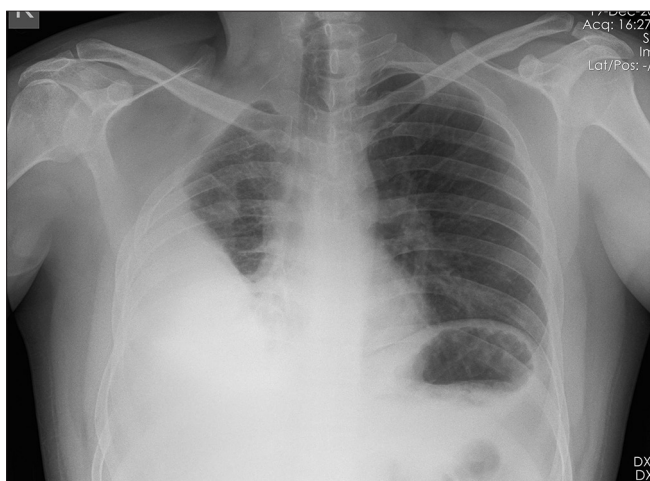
Chest X-ray showing moderate right-sided pleural effusion with osteolysis of the right first and second ribs
